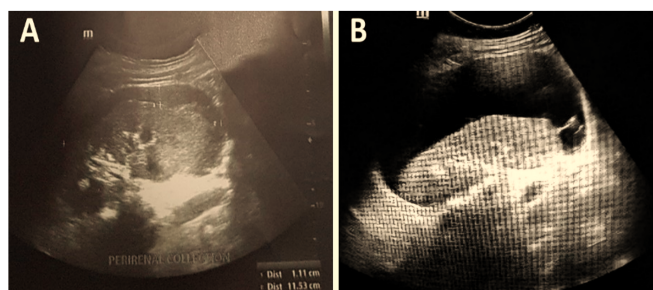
Renal ultrasound at the time of presentation (A: Right kidney, B: Left kidney) demonstrate echo-free areas surrounding both kidneys. The area is more pronounced on the left side, where it is accompanied by significant compression of the renal parenchyma.
